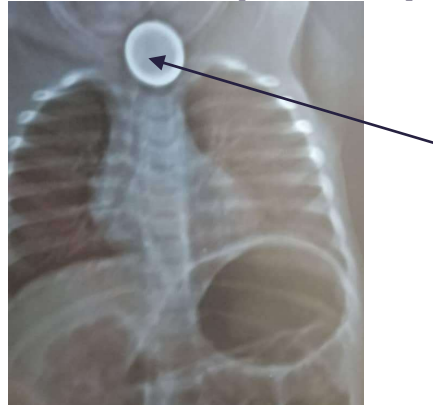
Chest X-ray in AP view of a 12-month-old known to have ingested a coin.
